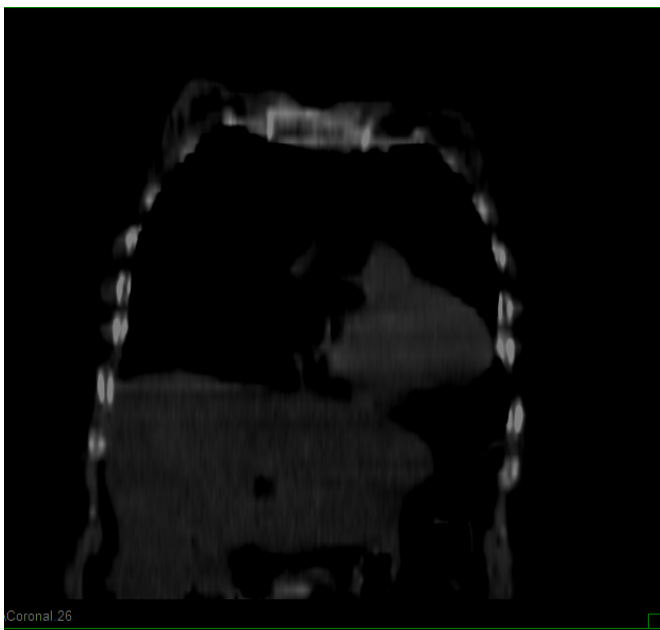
Coronal section of CT showing pleura lipoma in right hemithorax with radiological findings of fat (-50 to -100 Hounsfield units).
